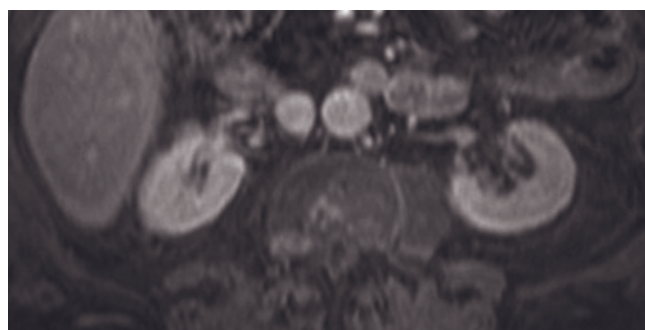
Normal kidneys. Coronal (a) and transverse (b) T2-weighted SS-ETSE, T1-weighted gradient-echo (c), T1-weighted fat-suppressed gradient-echo (d), immediate postgadolinium gradient-echo (e), and axial (f) and sagittal (g) interstitial-phase fat-suppressed postgadolinium T1-weighted gradient-echo images. Corticomedullary differentiation is best seen on pregadolinium
